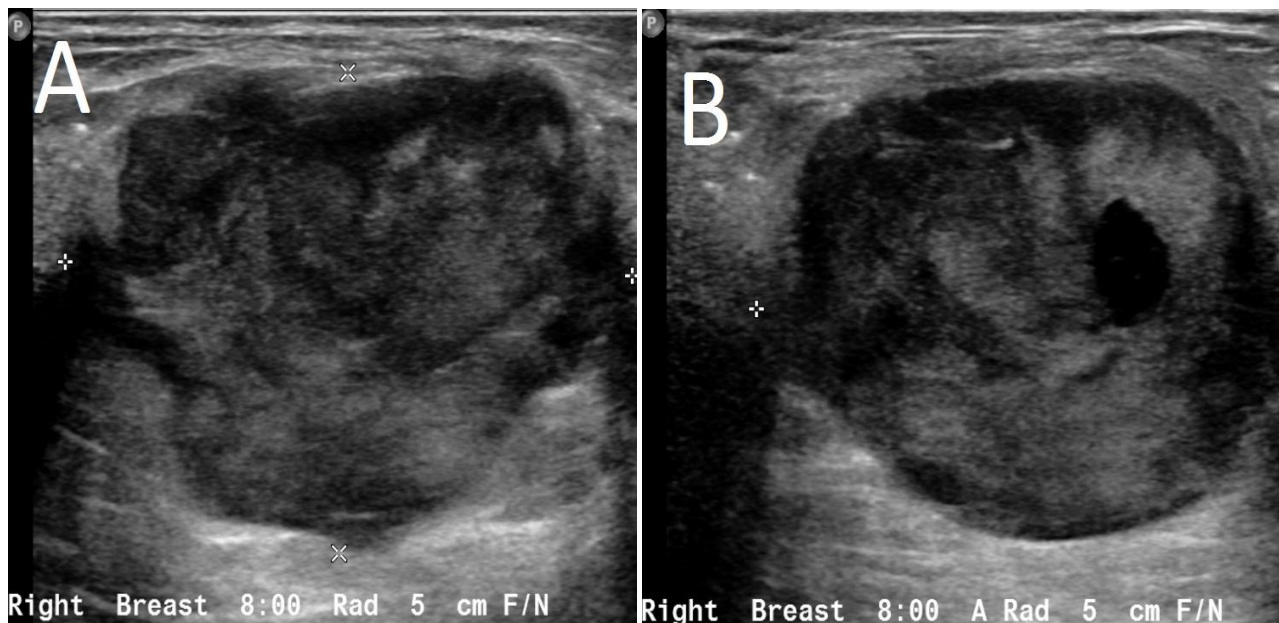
Right breast ultrasound showing a hypoechoic mass with circumscribed margins at the 8:00 5 cm from nipple, corresponding to the mass seen on the mammogram.
